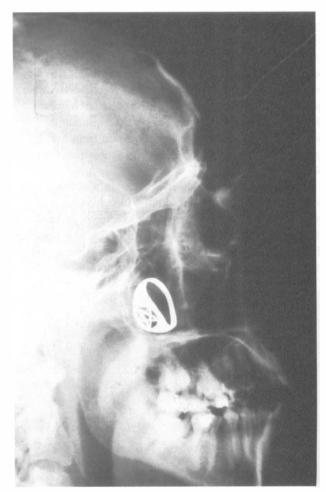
Skull radiograph showing a signet ring in the left maxillary sinus.*
